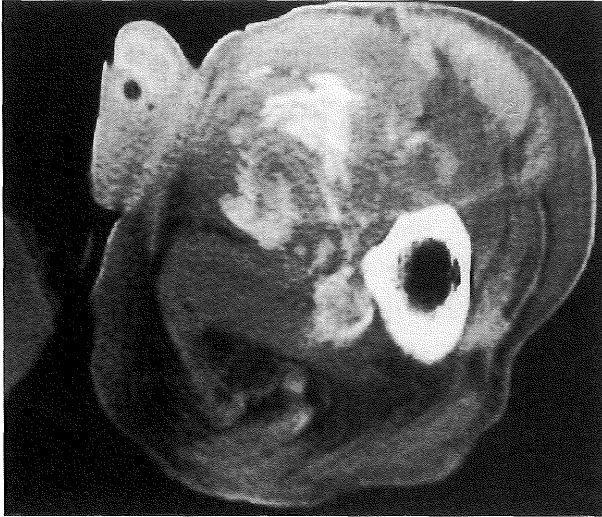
Computed tomography of the pelvis and femur showing that a mass approximately 10cm by 10 cm by 8cm in size was located in the quadriceps muscle of the thigh, and that the mass consisted of severe calcification.
